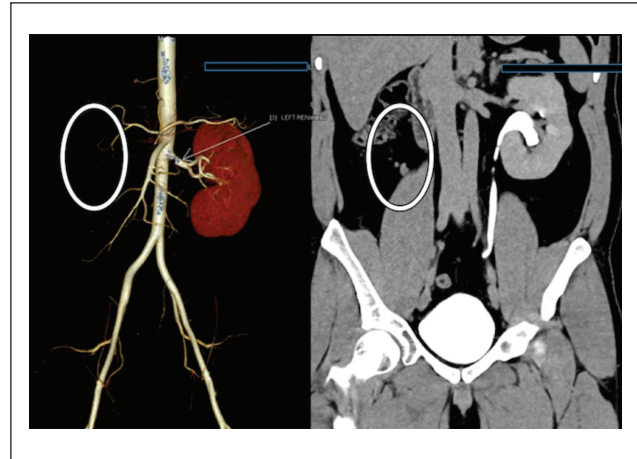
The MRI revealed a normal course of the left kidney and ureters, with no evidence of a right kidney or ectopic kidney. The left kidney was observed to be dilated, measuring 14.2 cm, and no other congenital abnormalities in the abdomen were noted during the scan.
